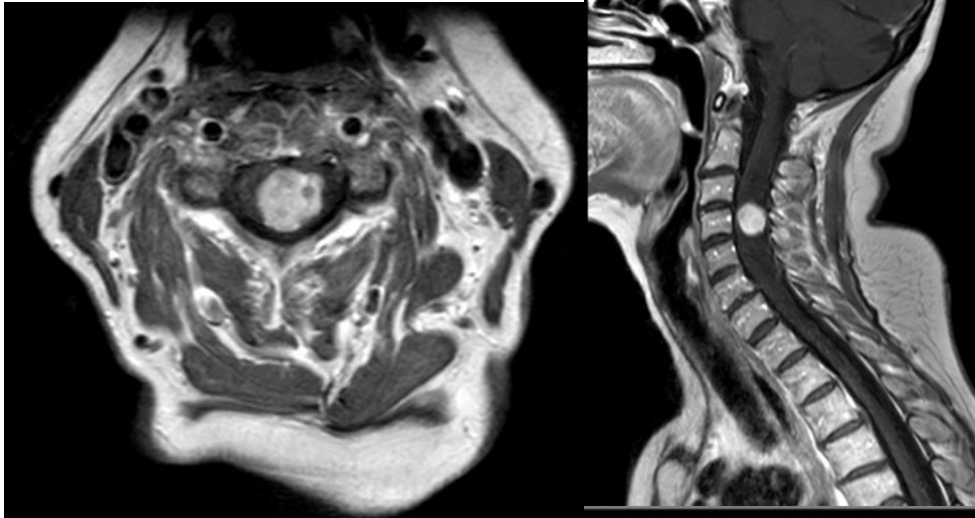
Pre-operative spinal MRI with contrast in axial and sagittal plan that show a neurinoma C4-5. In this case was performed a laminotomy
